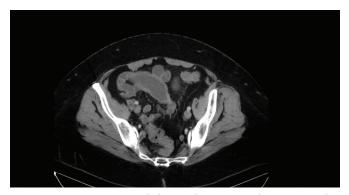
Transverse Abdominal Computed Tomography demonstrating isolated small bowel stricture.
